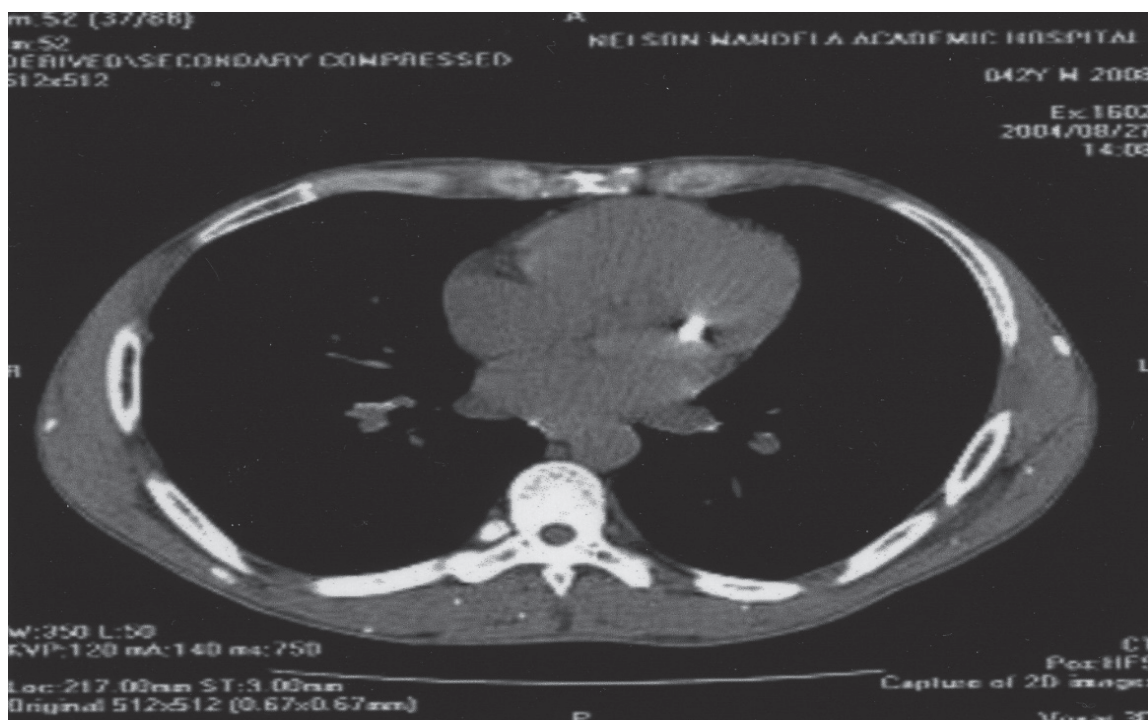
CT scan of chest confirmed the presence of cysts within the myocardium.[60]
